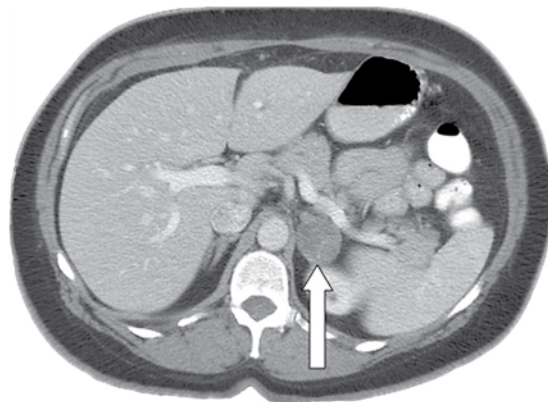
Axial computed tomographic image of an asymptomatic patient with an incidentally discovered 2.5-cm left adrenal mass (arrow). This mass has an imaging phenotype consistent with a cortical adenoma: it is hypodense, not vascular, and homogeneous. The Hounsfield unit density before contrast medium administration was -5 . Ten minutes after administration, there was 70% contrast washout.
